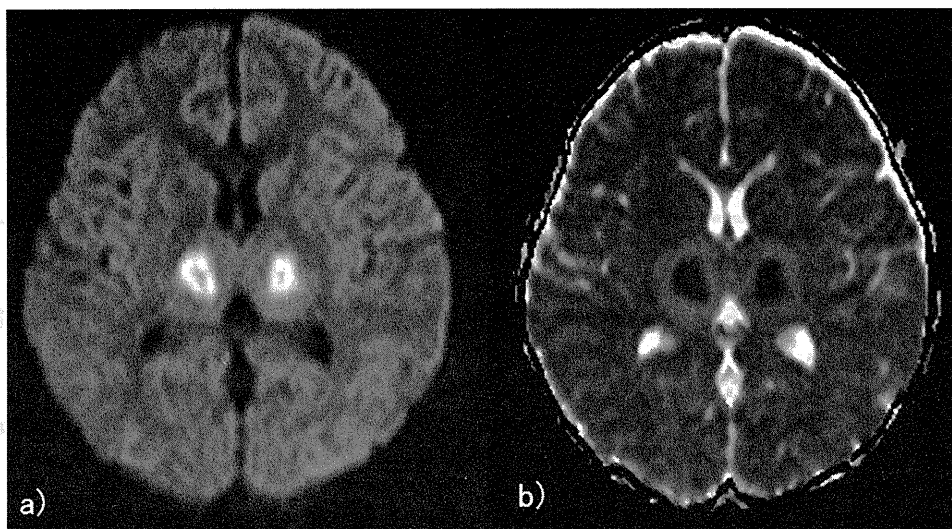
Cranial magnetic resonance imaging at 20 hours after the patient's convulsion. (a) Axial diffusion image indicates reduced diffusion (manifested as hyperintensity) in the symmetric thalamic lesions. (b) Axial apparent diffusion coefficient mapping indicates small, high lesions at the center of the thalami, with low lesions and high lesions around them.
